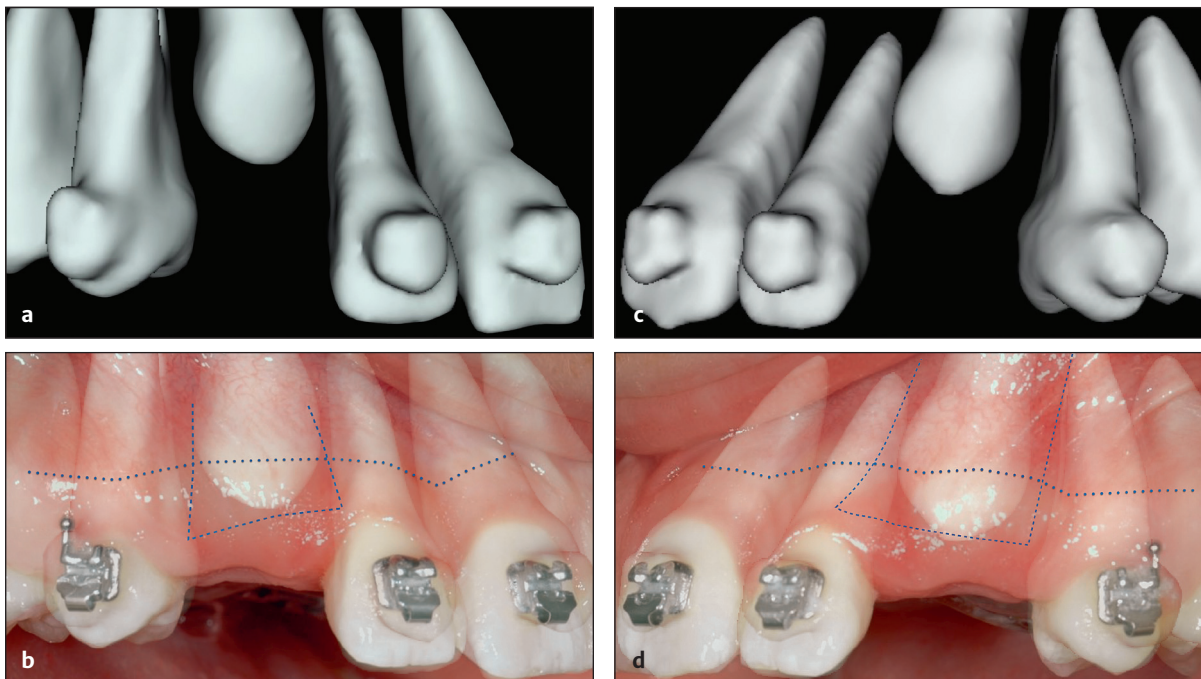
(a to d) 3D superimposition of the 3D CBCT model over the clinical photographs with outlined MGJ used in planning the apically positioned flap.
